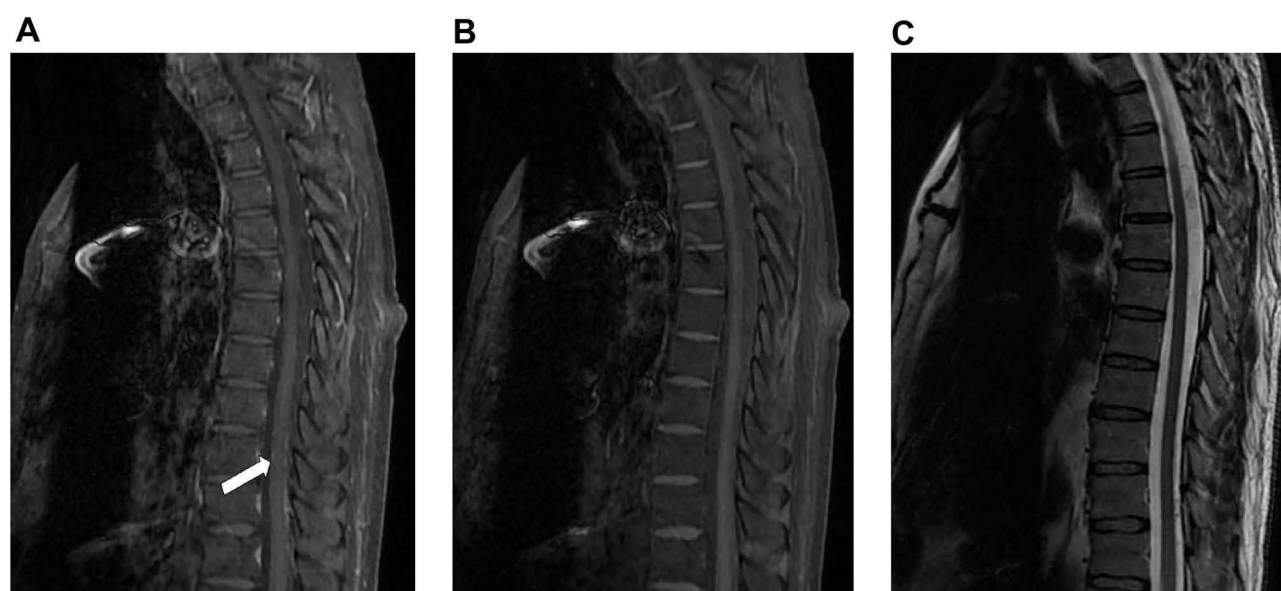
Thoracic spine MRI scan of neurosyphilis patients with LESC showed point enhancement of leptomeningeal surface lesions in T1 hyperintensity. (A) Sagittal T1-postgadolinium images reveal leptomeningeal enhancement (arrow). (B) T1-weighted sagittal image. (C) T2-weighted sagittal image.
